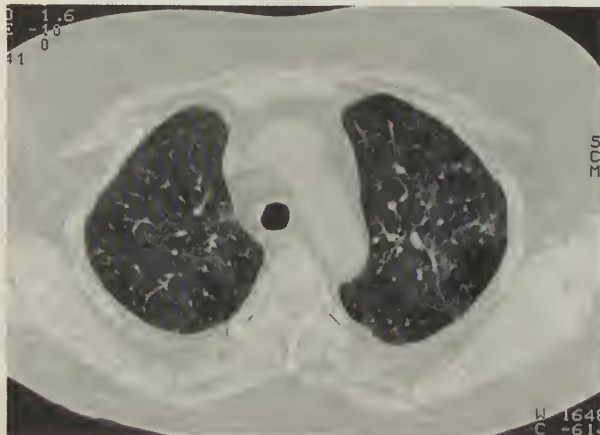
CT scan, in addition to emphasizing the linear nature of the lower lung changes, showed extensive "ground glass" infiltrates in both upper lungs suspicious for *Pneumocystis carinii* or cytomegalovirus pneumonia.
